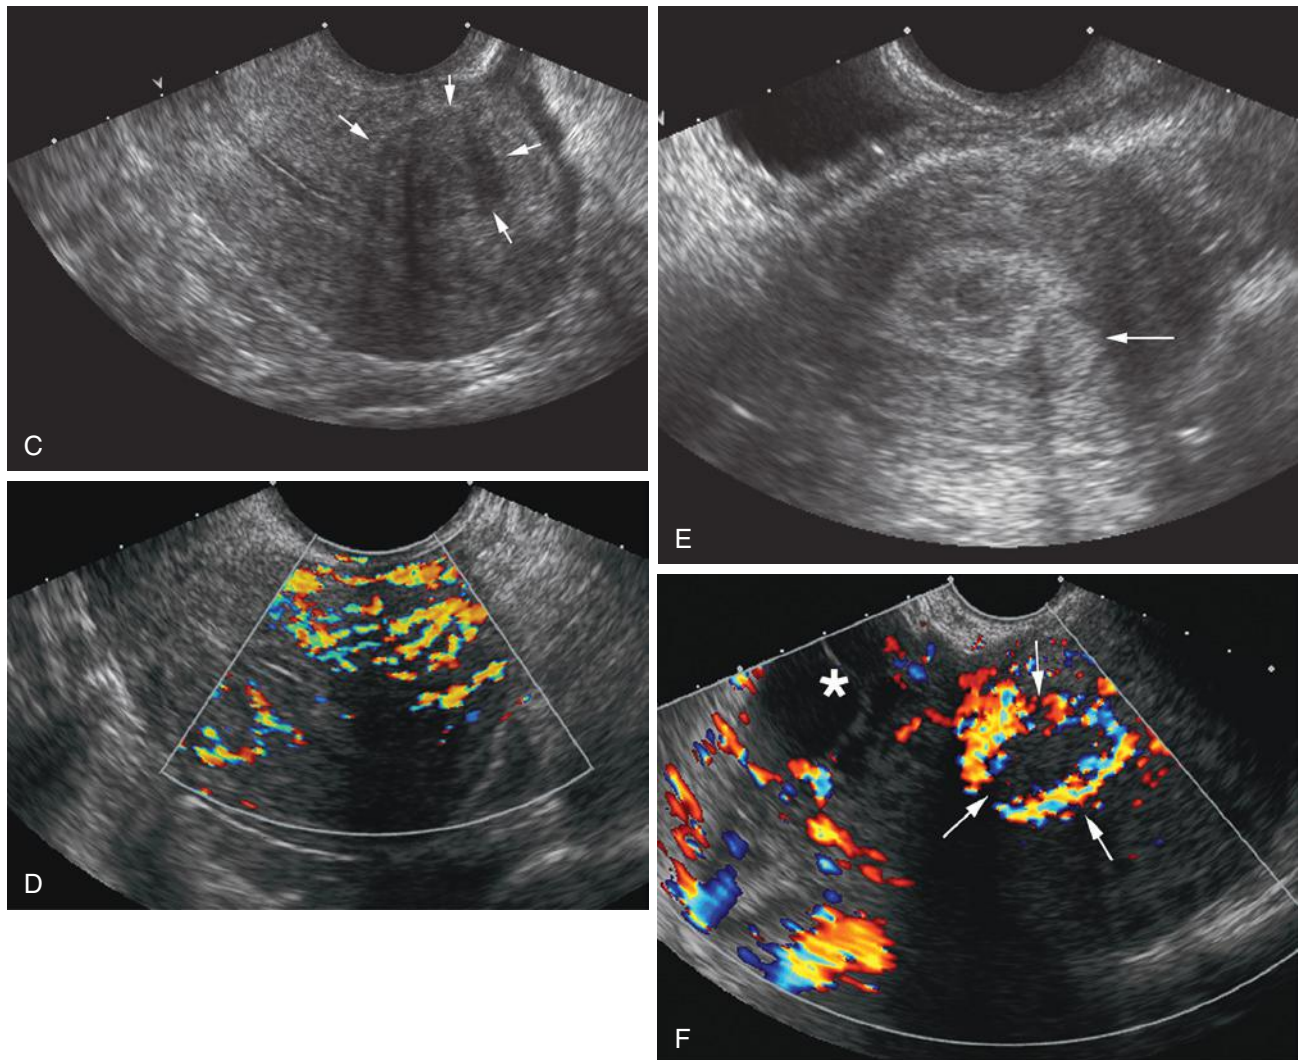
cont'd C, Transvaginal sonogram in a patient with a focal hypoechoic adenomyoma (*arrows*). On gray-scale imaging it can be very difficult to differentiate a focal adenomyoma from an intramural leiomyoma. D, Color Doppler image of the same patient in C, demonstrating increased vascularity within the adenomyoma. Such increased vascularity would be atypical for a leiomyoma. E, Another patient with an adenomyoma. In this case the adenomyoma is hyperechoic (*arrow*), indenting but separate from the endometrium. F, Transvaginal color Doppler image of a patient with an adenosarcoma arising in the background of adenomyosis with sarcomatous overgrowth. Note intense peripheral vascularity (*arrows*) surrounding a mass thought to represent an adenomyoma arising in the background of diffuse adenomyosis. A large cystic and solid mass (*asterisk*) is seen on the right, which was thought to be of ovarian origin.
